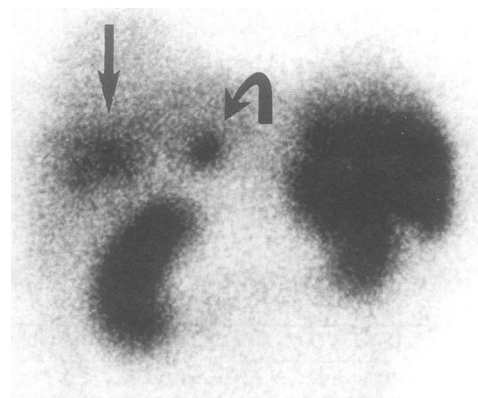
First SRS in patient 4 (table 5) showing a large, diffuse, and poorly delineated hot spot in the right liver lobe (arrow) and a smaller well delineated hot spot in the duodenopancreatic area (curved arrow). The smaller hot spot disappeared after surgical resection of a duodenal gastrinoma and tumoral lymph node. The liver remained normal with US and MRI after 52 months of follow up.
